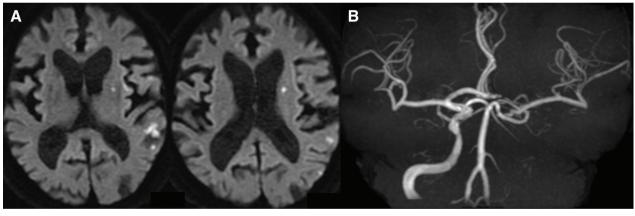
Diffusion-weighted MRI on postoperative day 1 reveals only spotty high-intensity lesions in the left insular and temporal lobes, with no infarction in the right hemisphere (\mathbf{A}) , and MRA demonstrates
